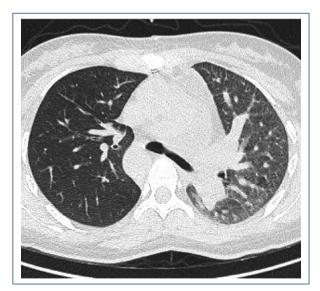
Axial CT lung window shows interstitial thickening and ground-glass appearance of left lung parenchyma.
